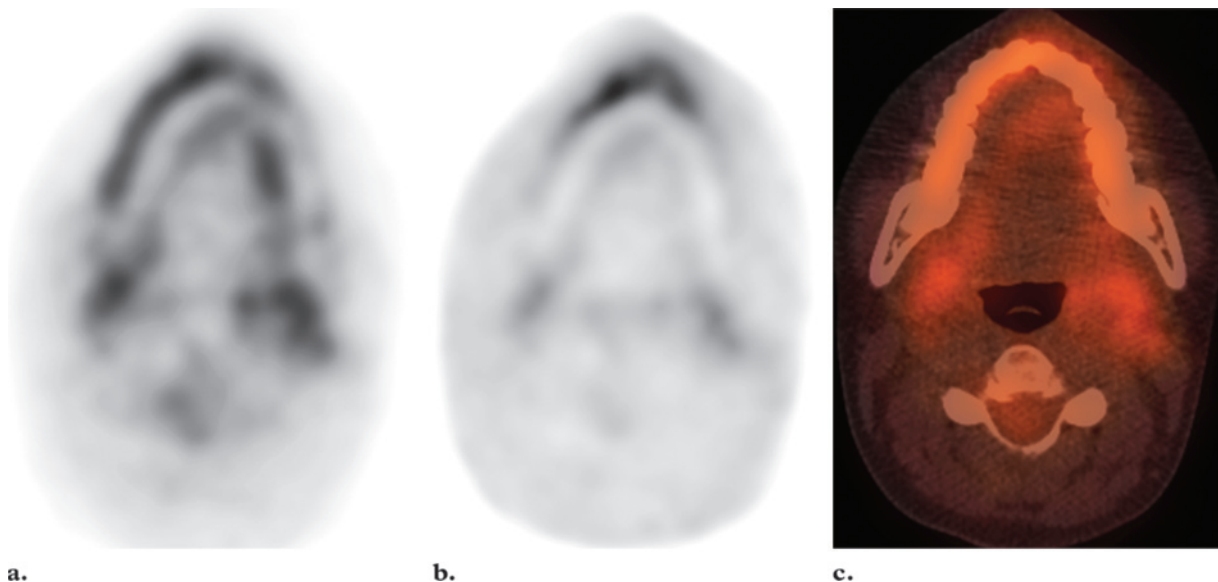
Motion artifact in a 16-year-old girl. (a) Transverse attenuation-corrected FDG PET scan shows artifactually high uptake along the outer aspect of the right mandibular body and along the inner aspect of the left mandibular body. (b) Non-attenuation-corrected FDG PET scan shows symmetric mandibular uptake. (c) Fused FDG PET/CT image shows artifactually high uptake corresponding to that shown in a. The symmetric mandibular uptake shown on the non-attenuation-corrected scan, along with the fact that there was no corresponding abnormality at CT, confirms that the uptake seen in a and c represents motion artifact.
